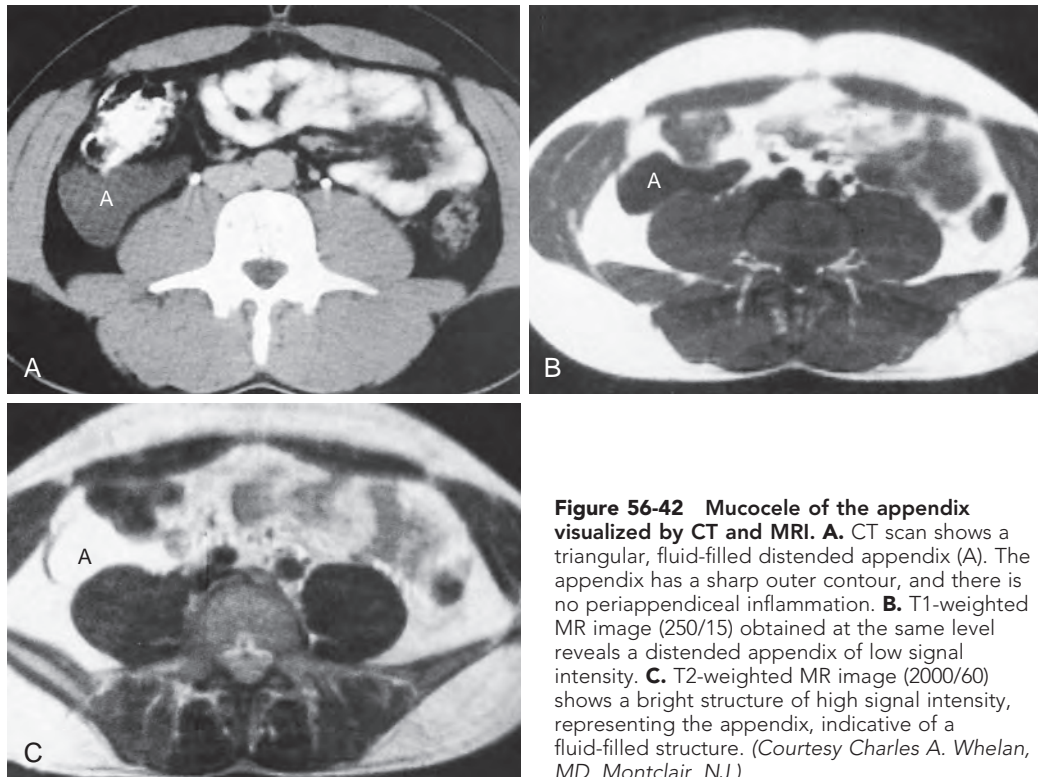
Mucocoele of the appendix visualized by CT and MRI. A. CT scan shows a triangular, fluid-filled distended appendix (A). The appendix has a sharp outer contour, and there is no periappendiceal inflammation. B. T1-weighted MR image (250/15) obtained at the same level reveals a distended appendix of low signal intensity. C. T2-weighted MR image (2000/60) shows a bright structure of high signal intensity, representing the appendix, indicative of a fluid-filled structure. (Courtesy Charles A. Whelan, MD, Montclair, NJ.)
